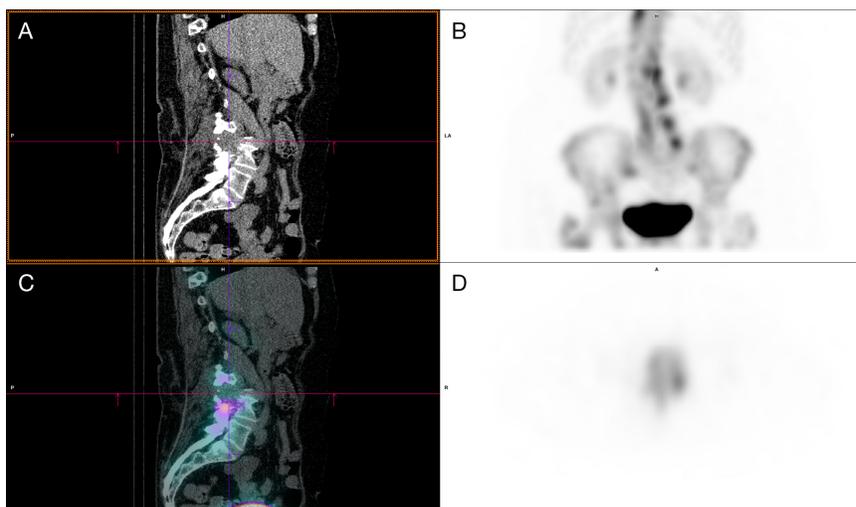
SPECT/CT taken 3 hours after IV administration of ^{99m}Tc MDP which shows that the lesion is photopenic, however a soft tissue mass and associated lysis of the right L4 pedicle is evident. A) Sagittal soft tissue reformat, non-contrast CT. B) Maximum intensity projection of SPECT/CT. C) Sagittal soft tissue fused SPECT/CT. D) Axial SPECT acquisition at L4 level.
